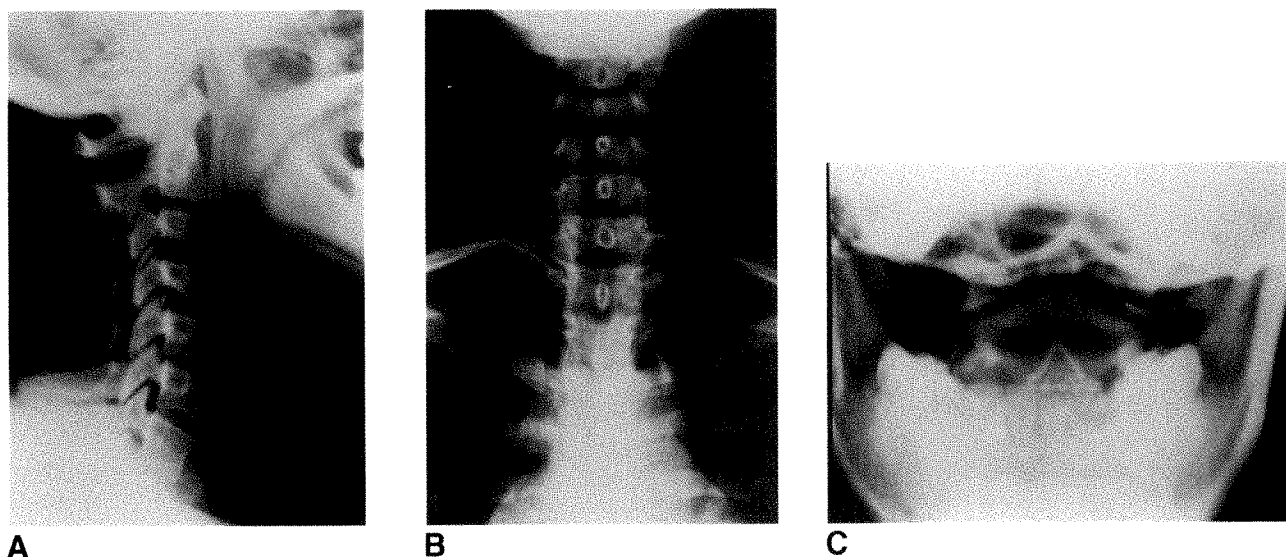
Standard roentgenographic views of a normal cervical spine. (A) Cross-table lateral, (B) anterior-posterior, (C) open-mouth.
